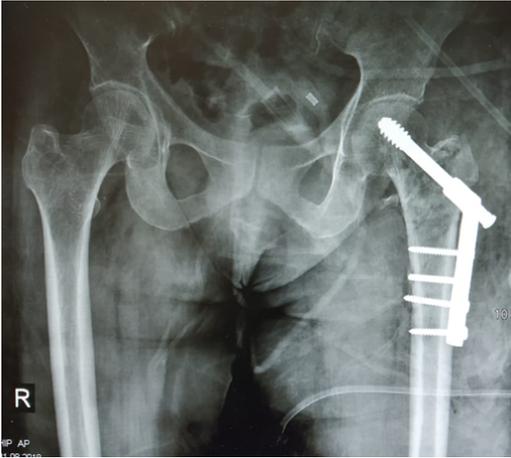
Post-operative Antero-posterior radiograph of Left sided Intertrochanteric femur Fracture treated with Dynamic Hip Screw
